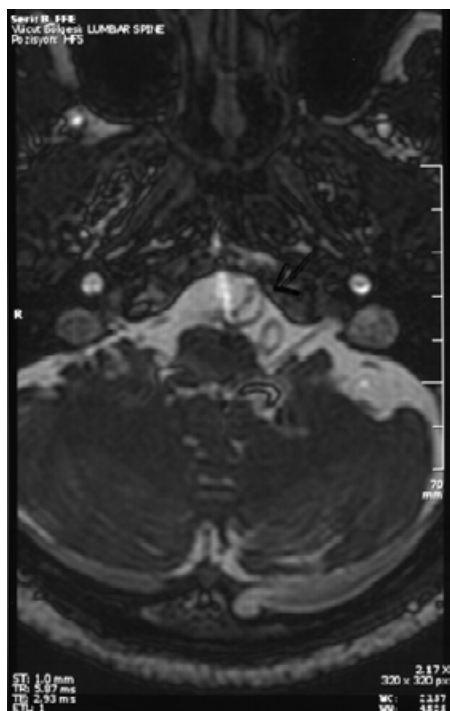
Temporal MRI, axial B-FFE sequence in a 27-year-old man. The left hypoglossal nerve is clearly seen.
